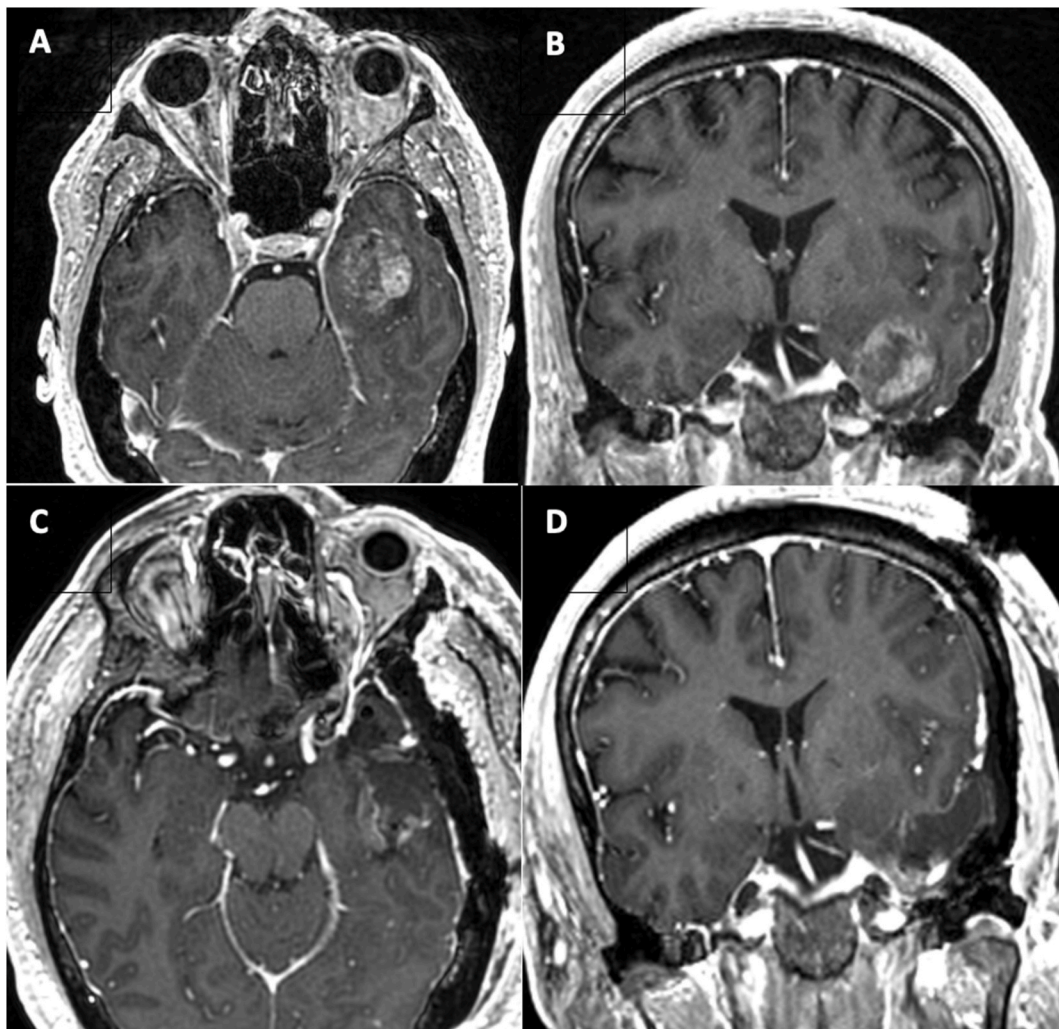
A.Pre-operative axial T1 post-contrast MRI showing a high-grade glioma of the left temporal lobe centered in the fusiform gyrus. B.Pre-operative coronal T1 post contrast MRI showing a high-grade glioma of the left temporal lobe C.Post-operative axial T1 post contrast MRI D. Post-operative coronal T1 post contrast MRI.
